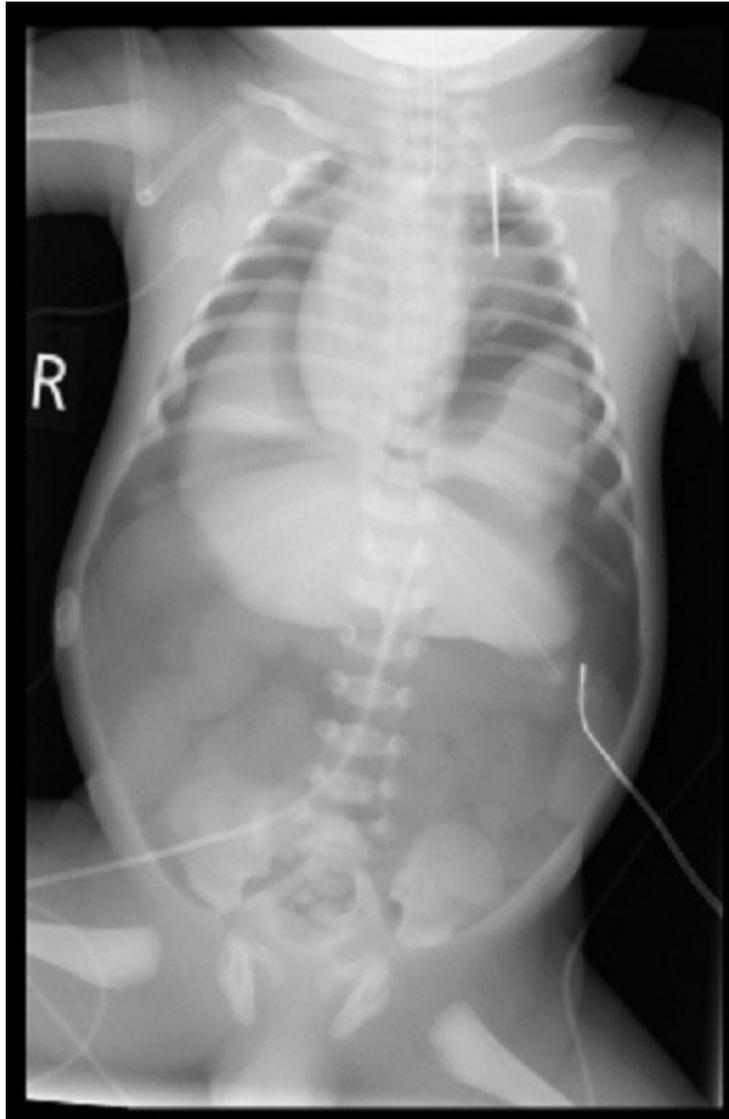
Plain Film imaging of the infant's chest and abdomen.
